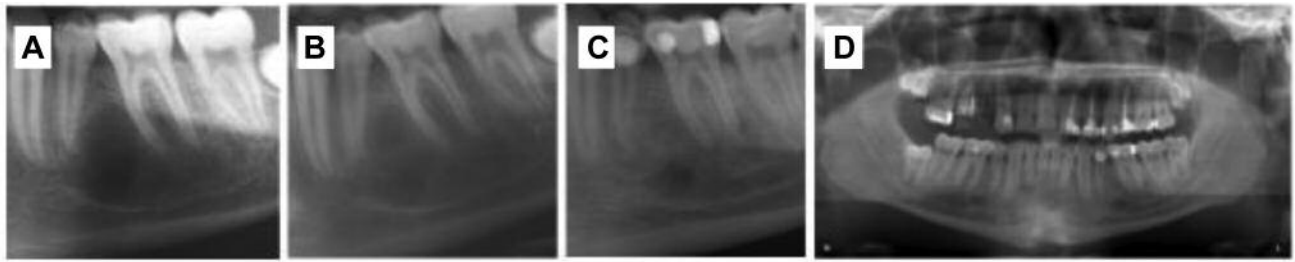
A series of radiographs depicting the region of a simple bone cavity of a male patient with neurofibromatosis type 1. A-C: cropped radiographs of panoramic views, D: panoramic view. A. There is periradicular and interradicular osteolysis in the area of the first premolar and the first molar of the left side of the mandible in a 24-year old male. The second premolar is missing (on both sides, see Figure 1D). The outlines of the tooth roots included in the osteolysis are intact. On the radiograph, the upper border of the nerve canal is not defined and the mental foramen can only be seen in shadow. B. Five months after the opening of the cavity, ossification of this area is evident. The mental foramen is skeletally defined. The upper border of the nerve canal is clearly visible in the former area of the cavity. C. Twelve years later, the area is completely ossified and indistinguishable from the surrounding bone. The mental foramen is skeletally defined. The upper border of the nerve canal is clearly visible in the former area of the cavity. D. As an incidental finding, there is periapical translucency of vital right lower second incisor in the 36-year old patient. The finding was not present on previous panoramic view 12 years ago and is compatible with the initial stage of periapical cemento-osseous dysplasia (57).
